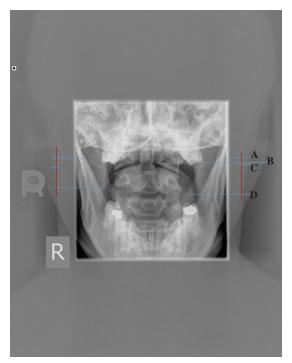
Radiometric method *True horizontal lines A, B, C, and D demarcate the inferior mastoid, C1 TVP, marker, and C2 TVP, respectively. The red vertical lines pass through the markers. Line B-C is examiner error for C1 TVP palpation, line A-C is maker-mastoid distance, and line D-C is C2 TVP–marker distance. In this exemplar radiograph, the right mastoid process and the upper surface of the left C1 TVP are difficult to visualize.*
